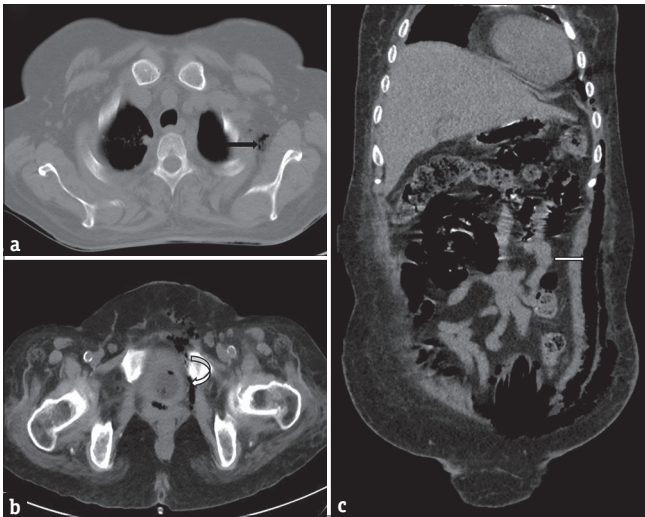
A 53-year-old female patient with emphysematous pyelonephritis with necrotizing fasciitis presented with breathlessness, pain in left lower hemithorax and in the left lumbar region. Noncontrast computed tomography thorax and abdomen with pelvis (a and b: mediastinal window - axial, c: coronal) showing necrotizing fasciitis in the left lateral chest wall up to left axilla (black arrow), along left lateral abdominal wall (white arrow) reaching up to perivesical fat (curved white arrow).
